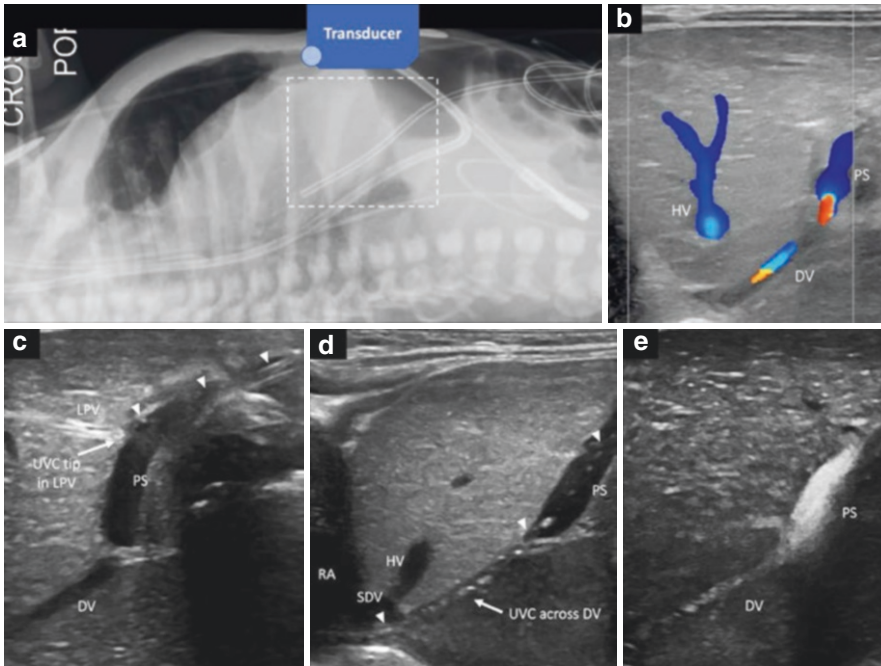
Ultrasound-guided umbilical venous cannulation. (a) lateral X-ray demonstrating the path of a correctly positioned umbilical venous catheter. White box corresponds to ultrasound imaging shown in panels b–e. (b, e) Color doppler (b) and agitated saline contrast (e) demonstrate ductus venosus patency; (c, d) Sagittal ultrasound images demonstrating an umbilical venous catheter
